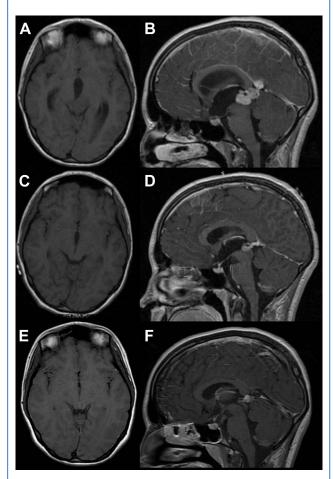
Case 1. Axial and sagittal T1-weighted images magnetic resonance imaging (MRI), respectively, before and after gadolinium administration showing a contrast-enhancing solid tumor mass of the pineal region, with aqueduct compression and obstructive hydrocephalus (A—B). MRI after 1 month (C—D) and after 6 months (E—F) demonstrating the spontaneous regression of the tumor, the progressive decrease in size of the third ventricle, and the patency of the aqueduct.
